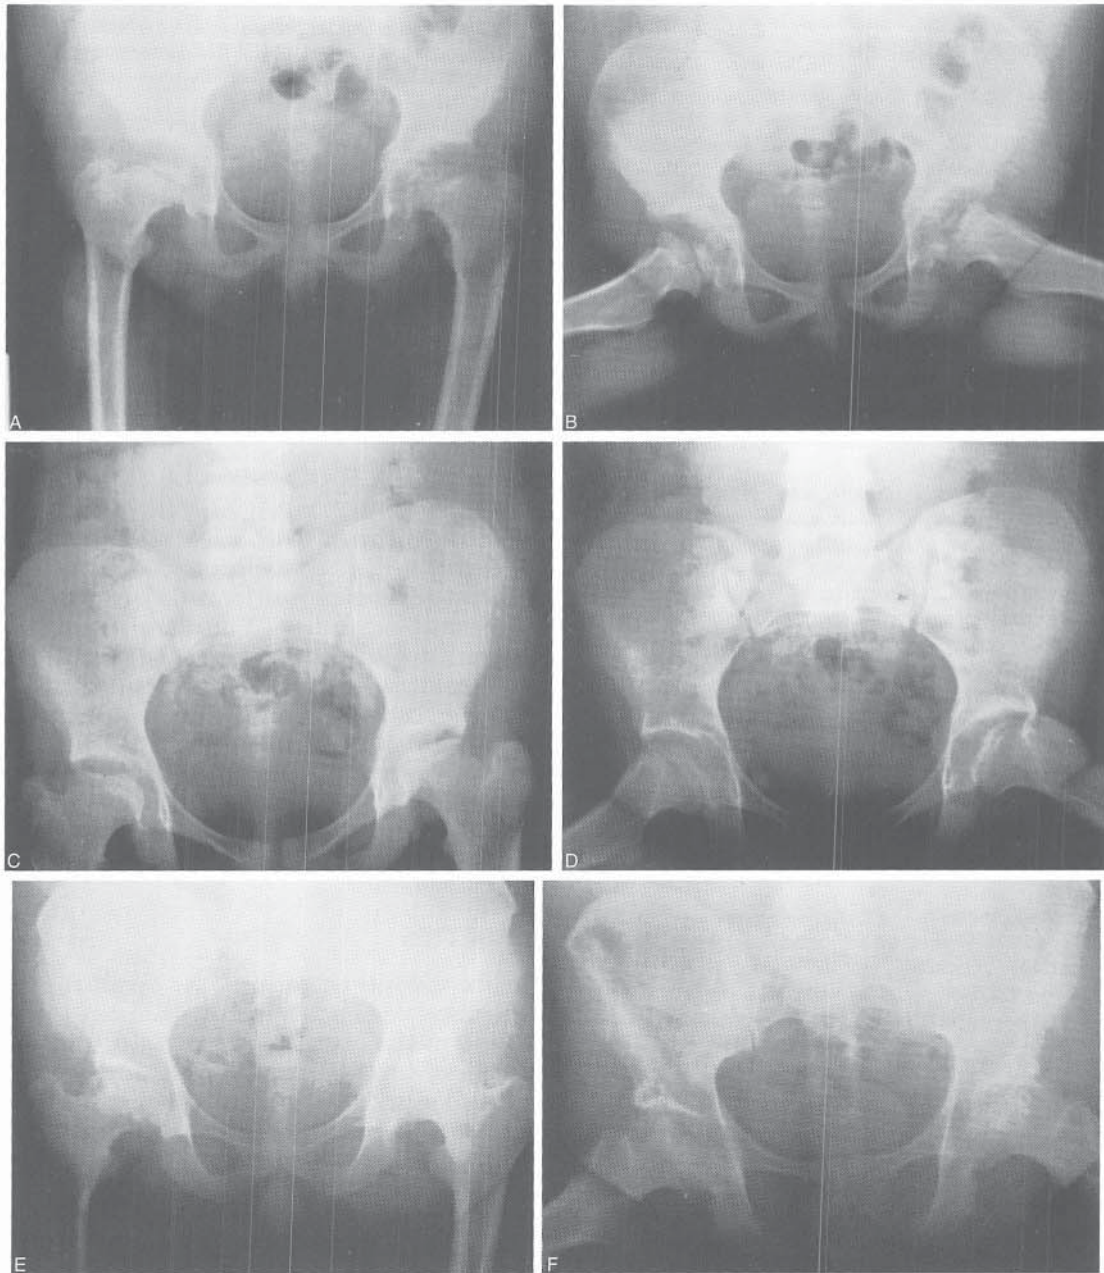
Multiple epiphyseal dysplasia in two sisters and their 40-year-old father. The disorder is inherited as an autosomal dominant trait. A and B, AP and frog-leg lateral radiographs of both hips of a 12-year-old girl. Note the irregularity and flattening of the capital femoral epiphyses. Involvement is bilateral. C and D, AP and lateral views of both hips of the 14-year-old sister showing similar changes. E and F, AP and lateral radiographs of the father's hips. Note the irregularity of the femoral heads and marked degenerative arthritis in both hips.
